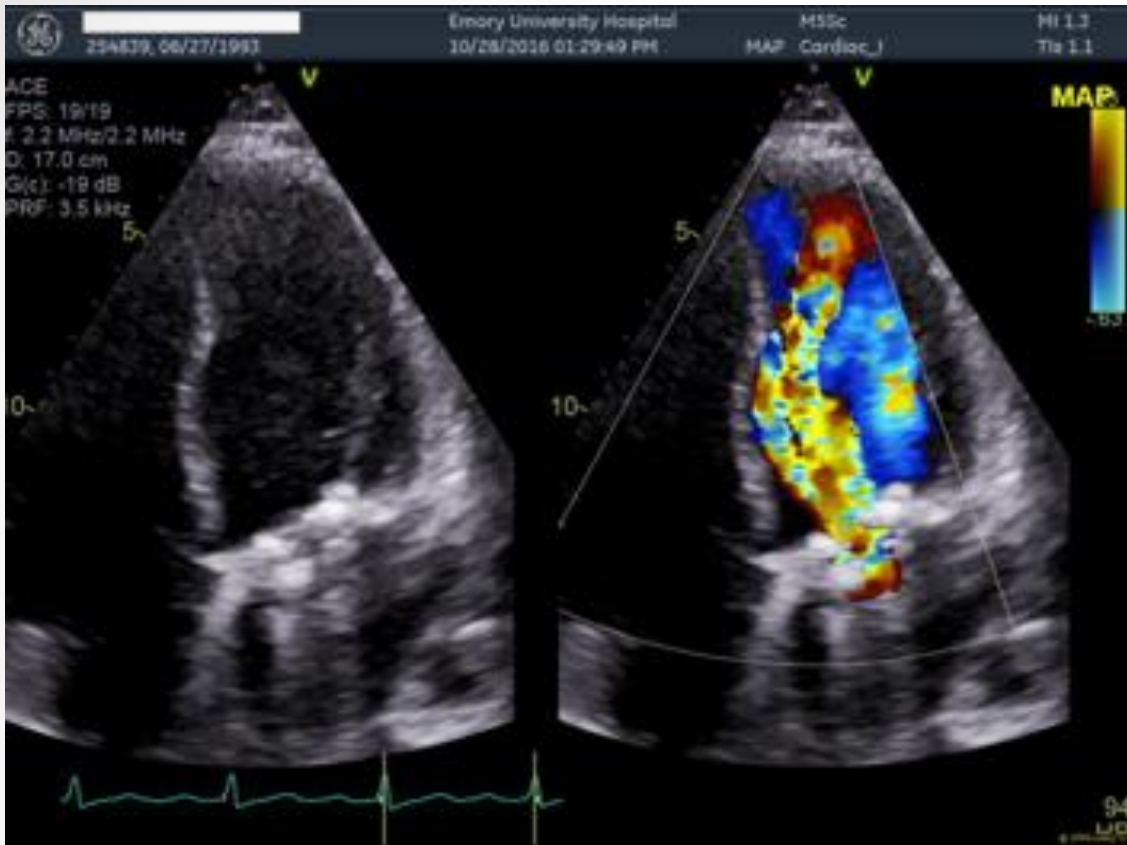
TTE at 24 wks reveals undersized MMV in place causing “functional” mitral stenosis with significant turbulent flow seen on doppler.
